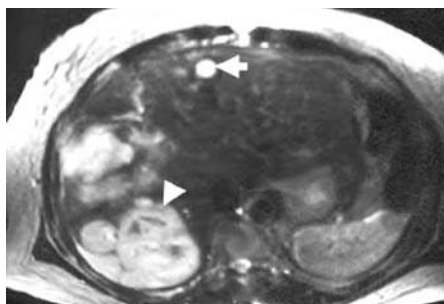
Both a liver cyst (arrow) and multiple right lobe liver metastases (arrowhead) are depicted on this T2-weighted SE (TR 2500, TE 80) image.
